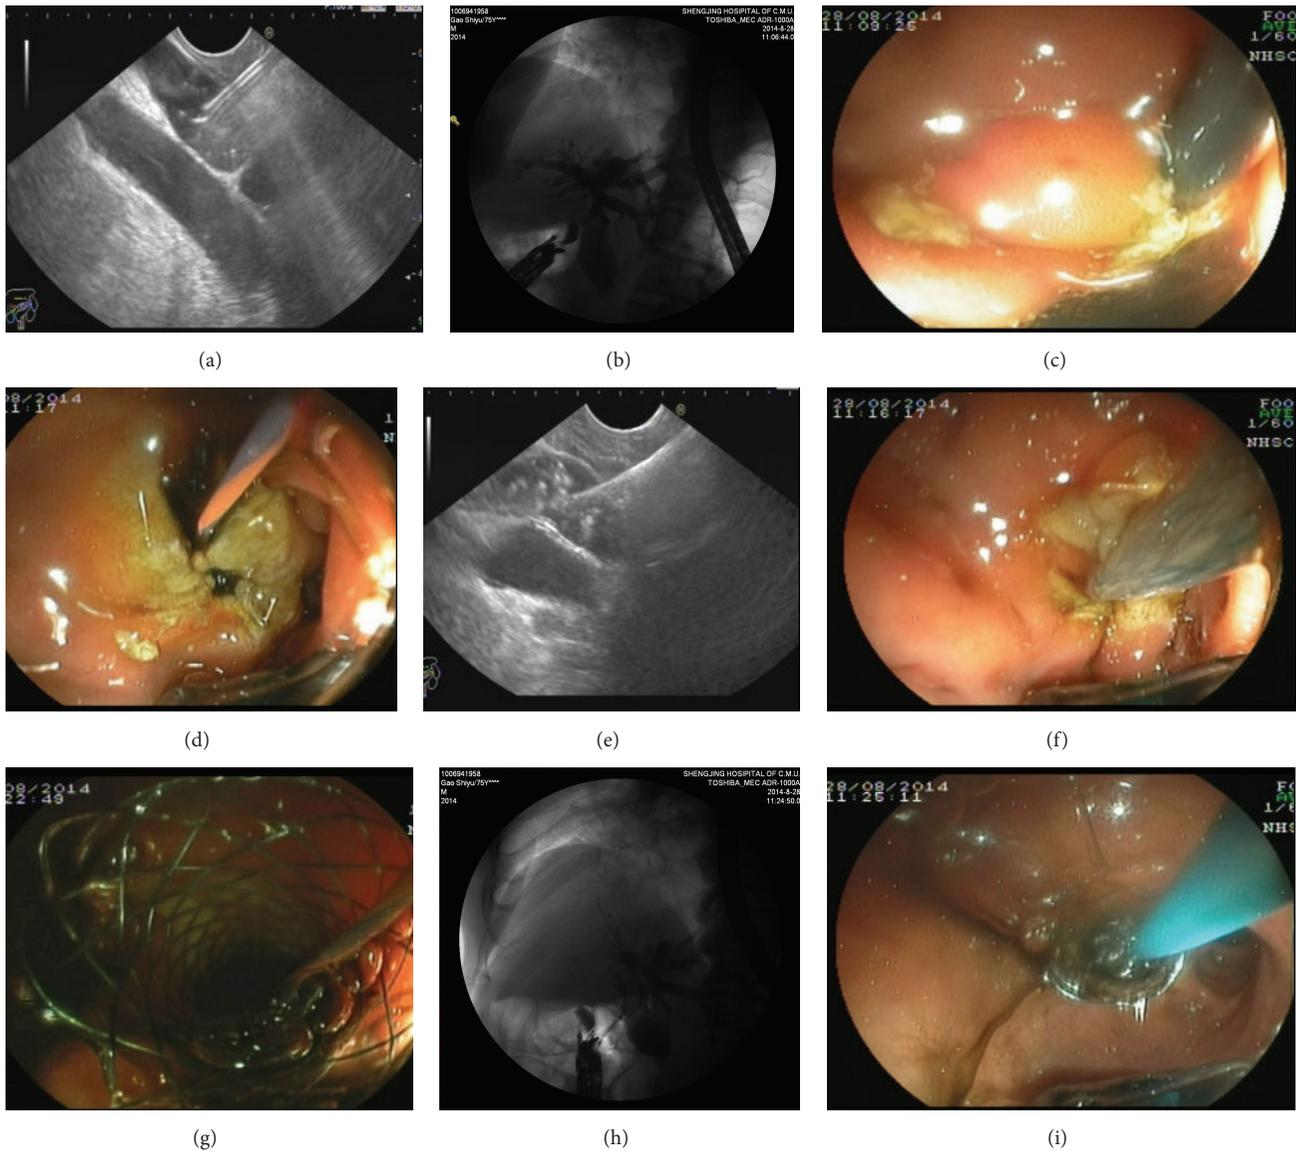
(a) Echoendoscope was advanced into the duodenal bulb. After checking local vasculature with color Doppler, the EUS puncture needle was then advanced into the intrahepatic duct. (b) Cholangiography was performed, which usually delineates the dilated biliary tree down to the point of obstruction. (c) The cystotome was used to create a fistula between the stomach and the left hepatic duct. (d) The puncture site after dilation. (e) The guidewire was observed under the EUS. (f)–(h) The fully covered SEMS was inserted and deployed transmurally. (i) To avoid bile leakage into the peritoneum, a 7 Fr nasobiliary was placed through the metallic stent.
